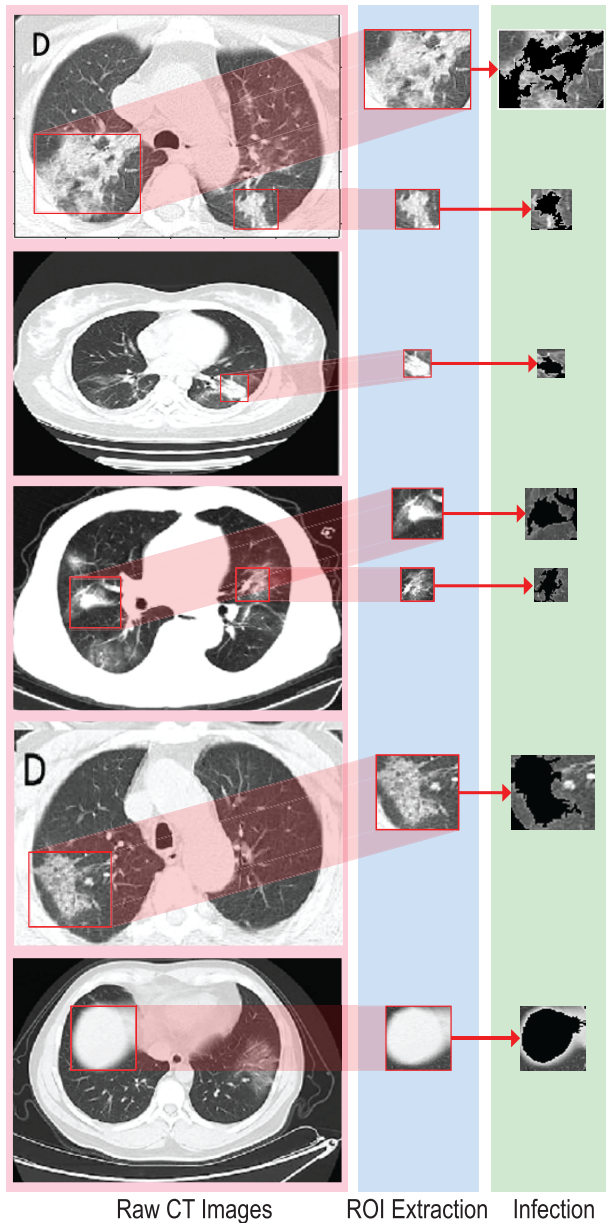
Infected region detection from raw CT lung image through region of interest extraction.
